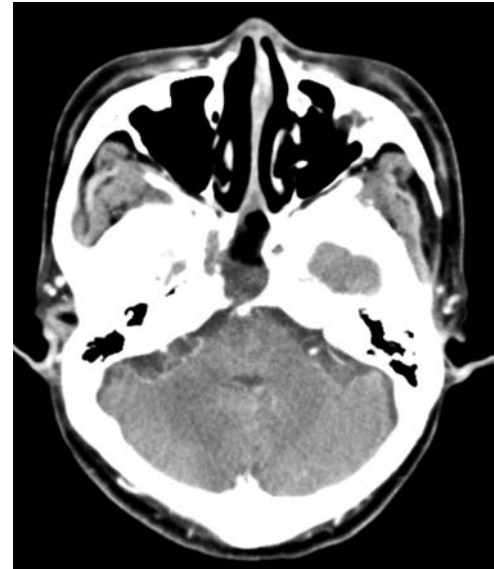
Follow-up brain CT at post-op 3 months showing no sign of tumor recurrence.
